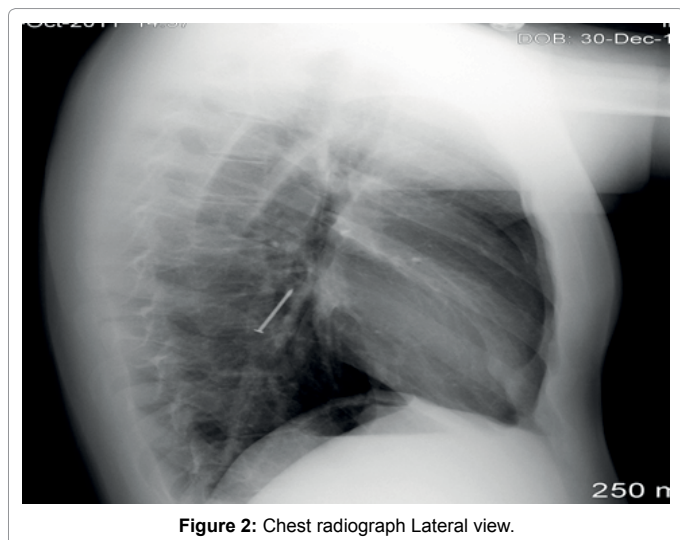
Chest radiograph Lateral view.
